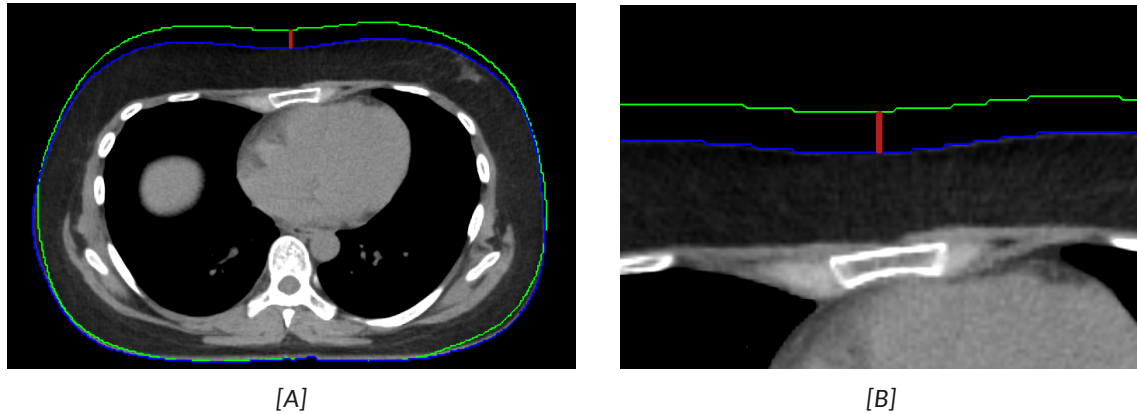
Axial CT images showing the primary point elevation on a real patient: [A] full thoracic view and [B] zoomed-in view of the same region.
